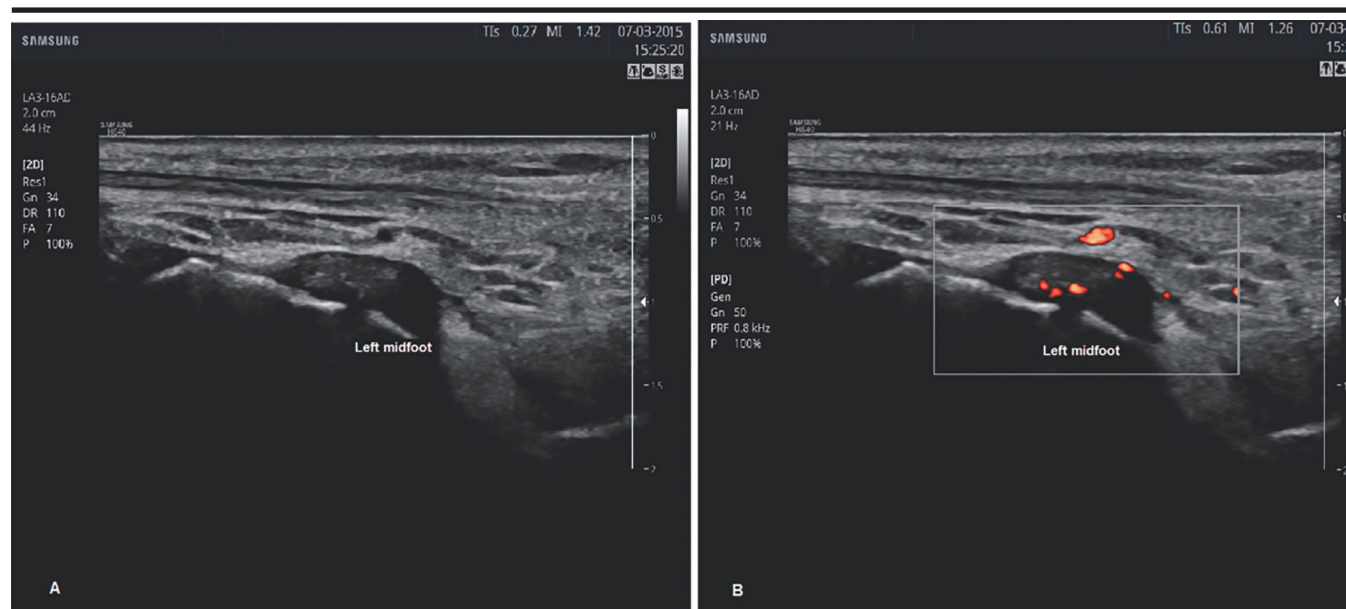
Ultrasonography:
